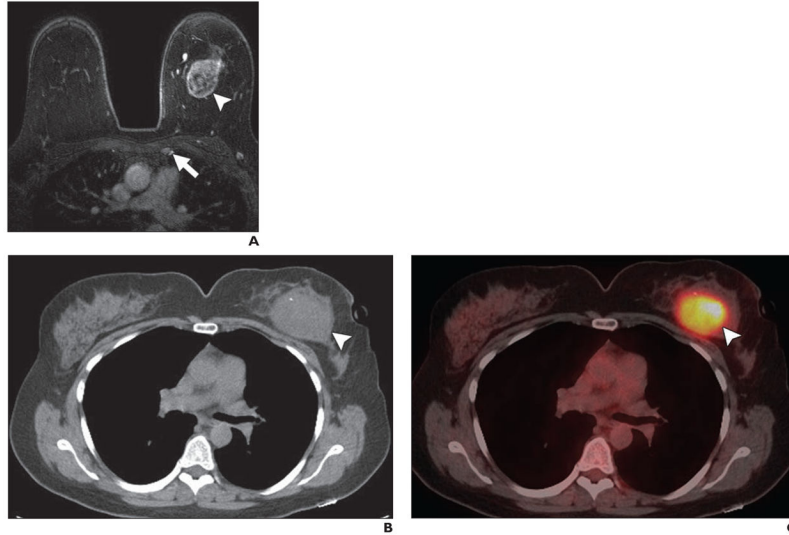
Left breast cancer with adenopathy of left internal mammary node in 42-year-old woman with highgrade infiltrating ductal carcinoma with necrosis. Pretreatment imaging included both MRI and PET/CT examinations, and adenopathy was evident on MRI but not on PET/CT.
